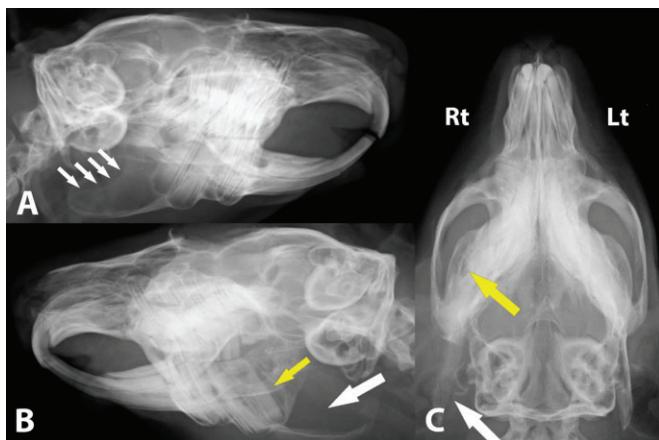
Skull radiographs. (A) Right 30° ventral-left dorsal projection. The white arrows highlight the normal dorsal border of the angular process of the mandible. (B) Left 30° ventral-right dorsal projection. The radiotransparent area caudal to the right third molar (M3) (yellow arrow) is consistent with periapical infection. Radiolucency of the angular process of the mandible is consistent with bone lysis (white arrow). (C) Ventrodorsal projection. Note the small radiolucent area at the right mandible (yellow arrow) and apparent lysis of the angular process (white arrow)
